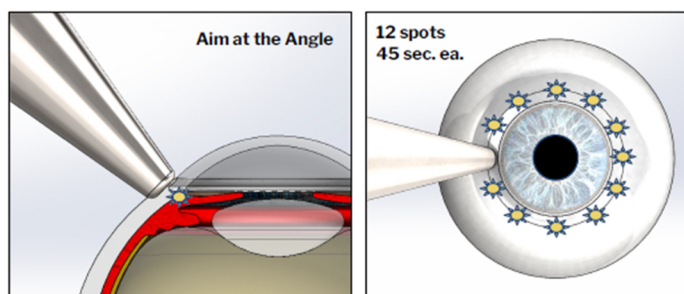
Standard TUG treatment protocol, in which low-power ultrasound is delivered to 12 spots around the limbus for 45 seconds each.
